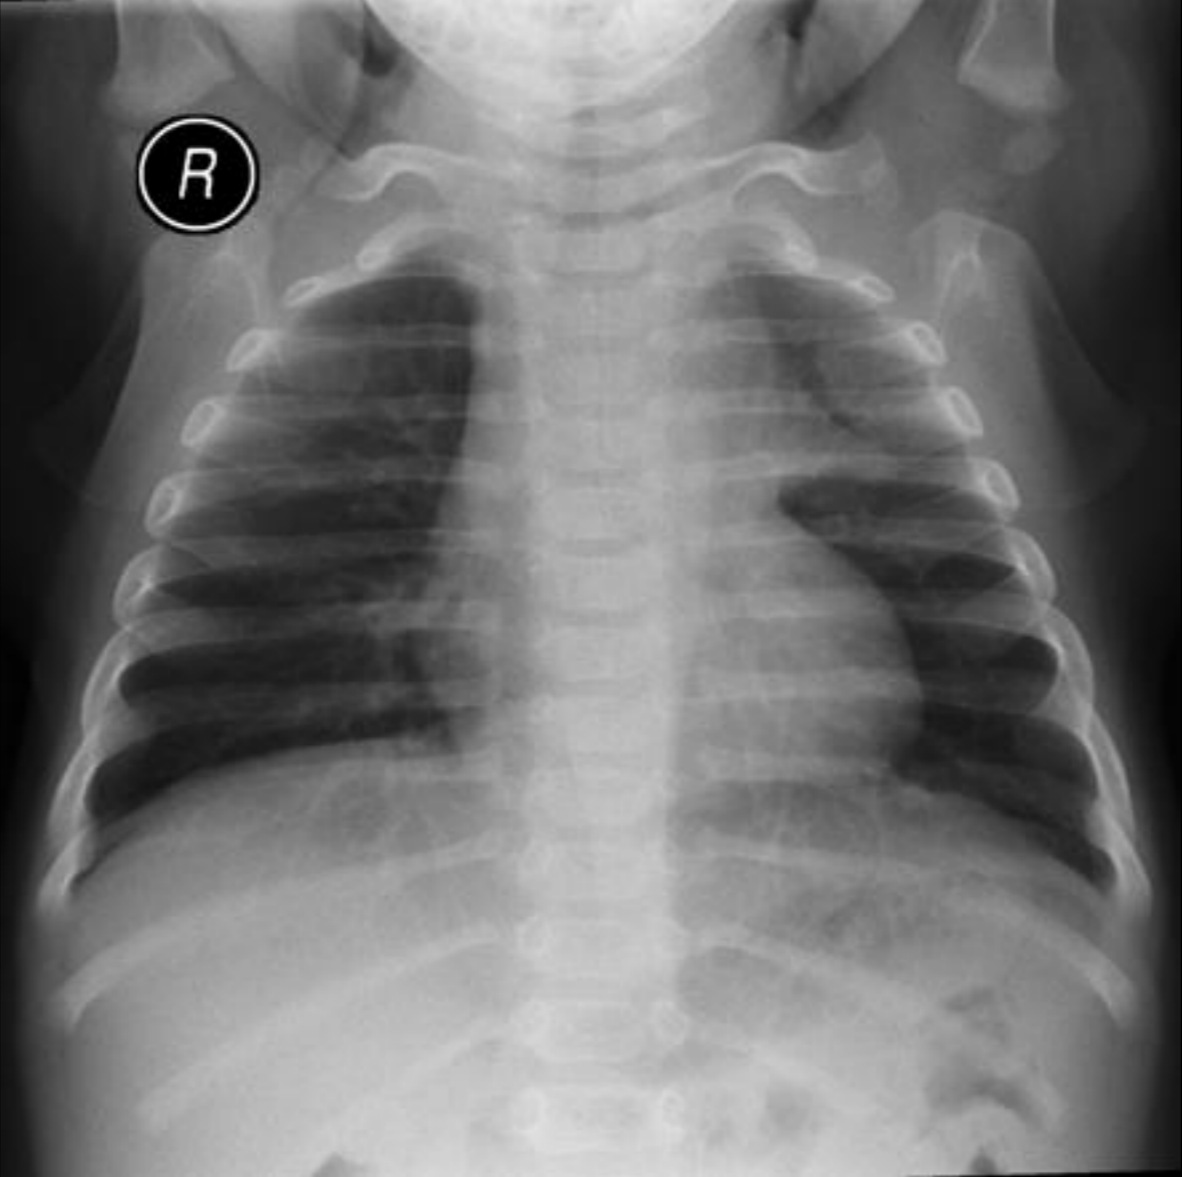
Three-hour-old newborn infant x-ray presenting the “sail sign” (arrow).
